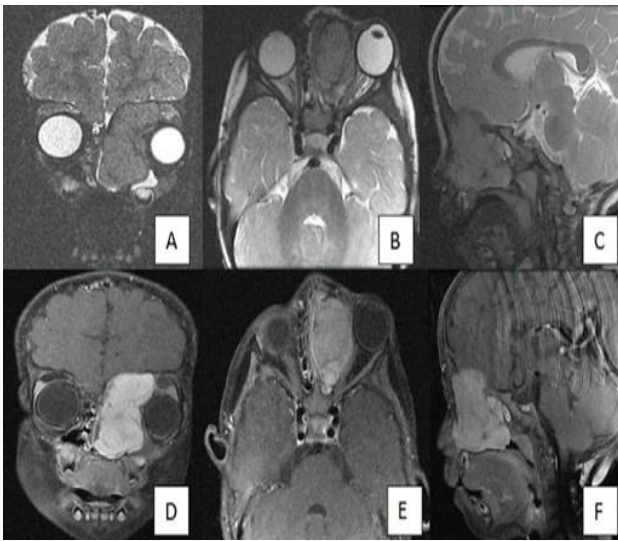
(A-F): MRI of orbits and paranasal sinuses reveals a large T2 hypointense lesion with epicenter in the left nasal cavity and ethmoid sinuses. Superiorly, it is seen to cause severe thinning of roof of the left frontal and ethmoid sinuses; inferiorly, bowing of the hard palate on left side; medially, deviation of nasal septum towards right side and laterally, protrusion into the extraconal spaces of the left orbit is seen. Significant enhancement of the lesion is seen in post contrast images.
